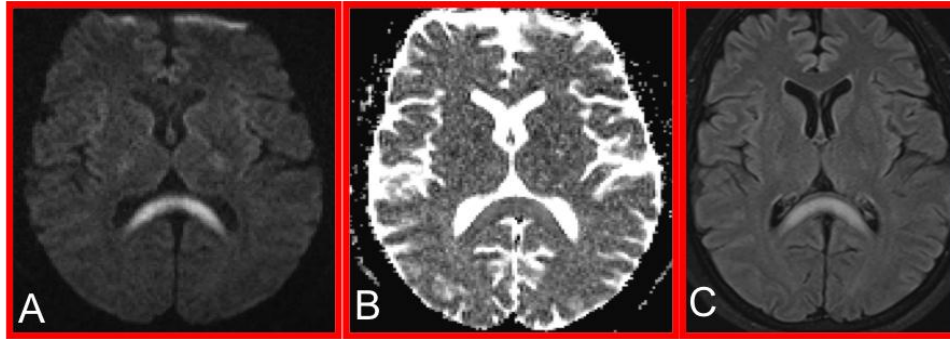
A: DWI, B: ADC, C: FLAIR. All three images are axial slices taken from the same level of the brain. The FLAIR imaging now demonstrates hyperintensity in the splenium of the corpus callosum. The hyperintensity seen in the DWI image likely represents T2 shine-through as there is no correlating hypointensity seen on the ADC sequence. The extensive bilateral periventricular restricted diffusion seen in Figure 1 has resolved
